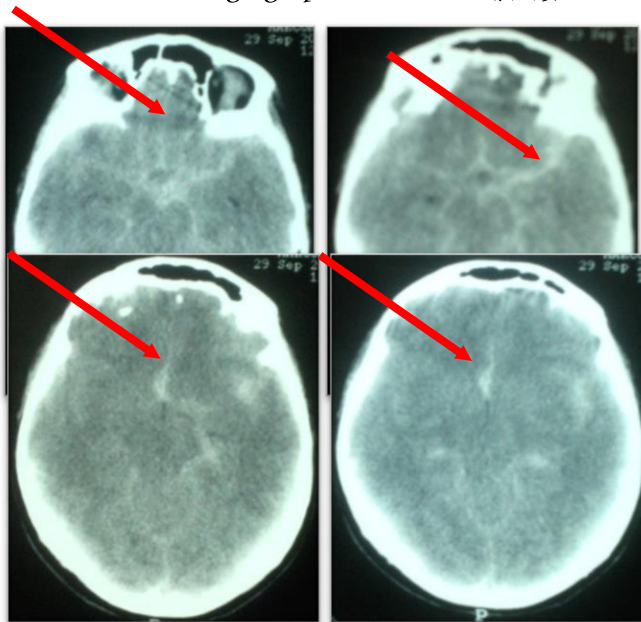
CT-scan: preoperative vasospasm of ACA. Patient is pharmacologically managed with nimodipine (calcium channel blocker)
